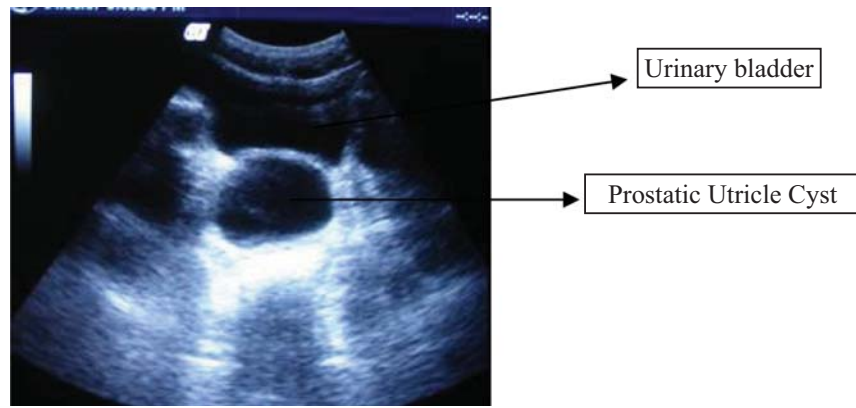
Ultrasound pelvis reveals a large anechoic cystic lesion posterior to the urinary bladder.
